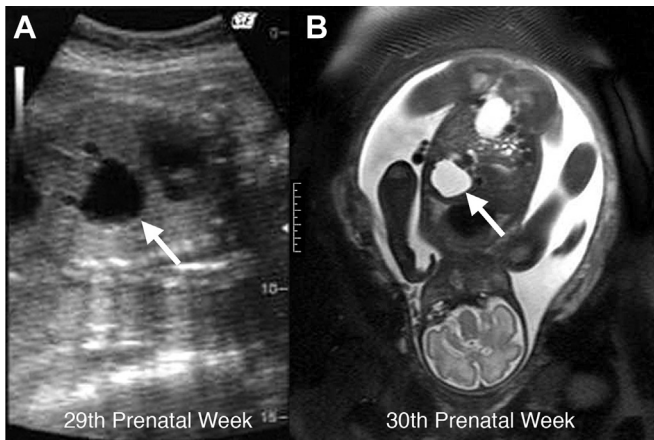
Maternal ultrasonography and magnetic resonance imaging before the birth of the patient. An intrahepatic or extrahepatic cystic lesion is apparent in the fetus (arrows). Hydramnios is not seen.
